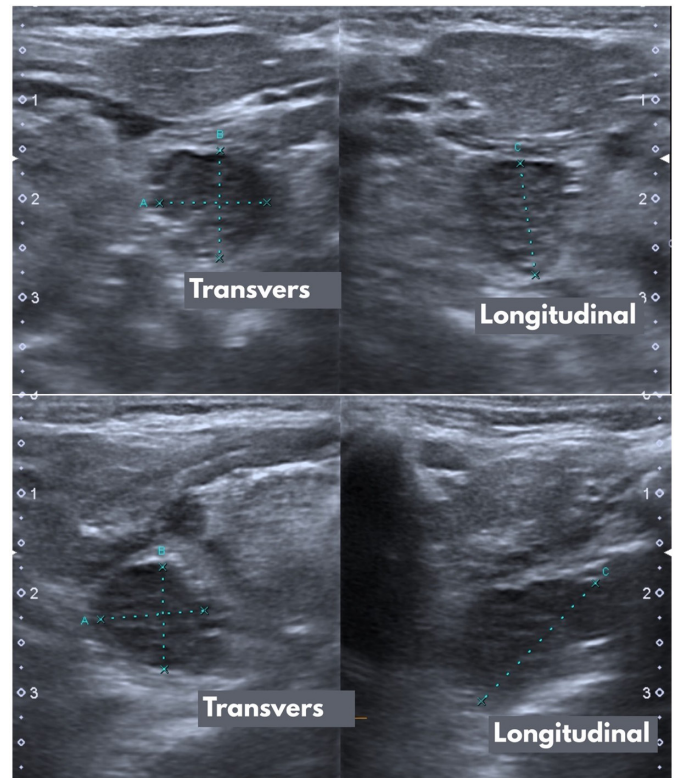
Sonographic measurement of palatine tonsil dimensions of 2 different patients.
